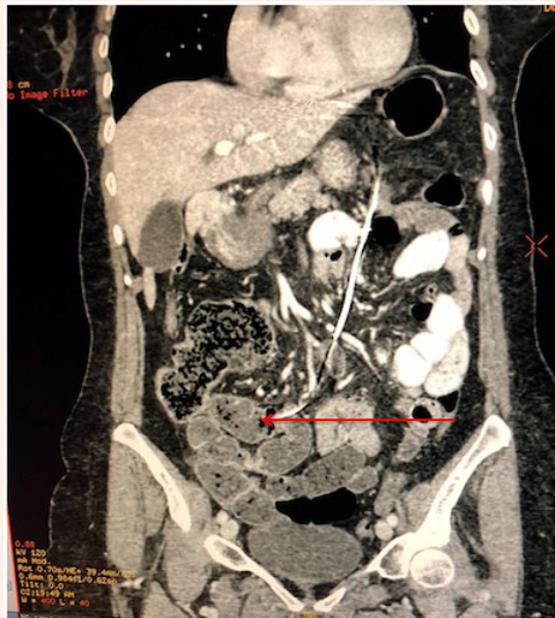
CT scan showing a distention of small bowel loops caused by the gastric pacemaker showed by the arrow
